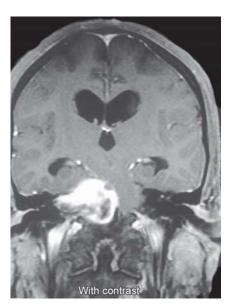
Gadolinium enhanced T1 weighted coronal MRI showing brightly enhancing acoustic neuroma tumor causing marked deviation of the brainstem to opposite side with hydrocephalus. *Note:* The extension of the tumor in internal auditory meatus (*Source:* Photo by Dr Bhavin Parikh)
